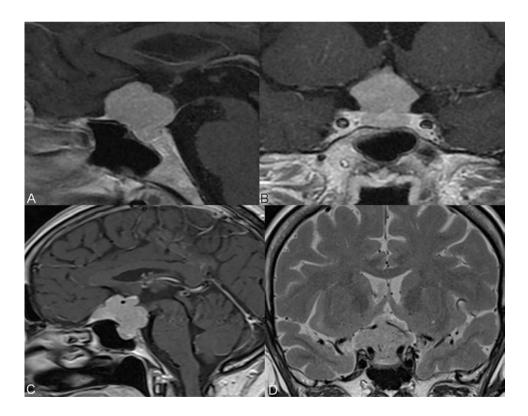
(a–d) Sagittal (a) and coronal (b) T1-weighted MRI scans showing a tuberculum sellae meningioma displacing the optic apparatus and pituitary stalk posteriorly. Sagittal (c) T1-weighted and coronal (d) T2-weighted MRI showing a tuberculum sellae meningioma encasing the anterior cerebral artery complex
